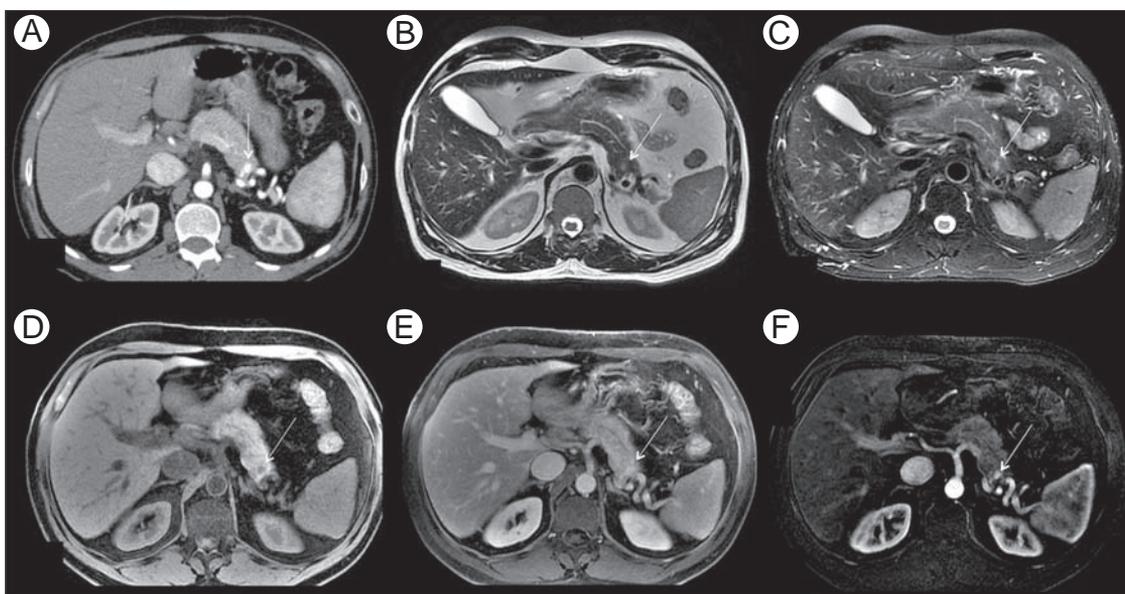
Hemangioma of pancreas in an asymptomatic 56-year-old man with history of non-Hodgkin lymphoma, previously treated with chemotherapy. The patient underwent distal pancreatectomy with a presumed diagnosis of a neuroendocrine tumor. Contrast-enhanced arterial phase CT image (A) demonstrates a small hypervascular nodule in the pancreatic tail (arrow), which is slightly hyperintense on T2-W images without (B) and with (C) fat suppression (arrows). The nodule is hypointense on unenhanced T1-W 3D GRE image (D), with a hypervascular pattern of enhancement (E and F) (arrows).
